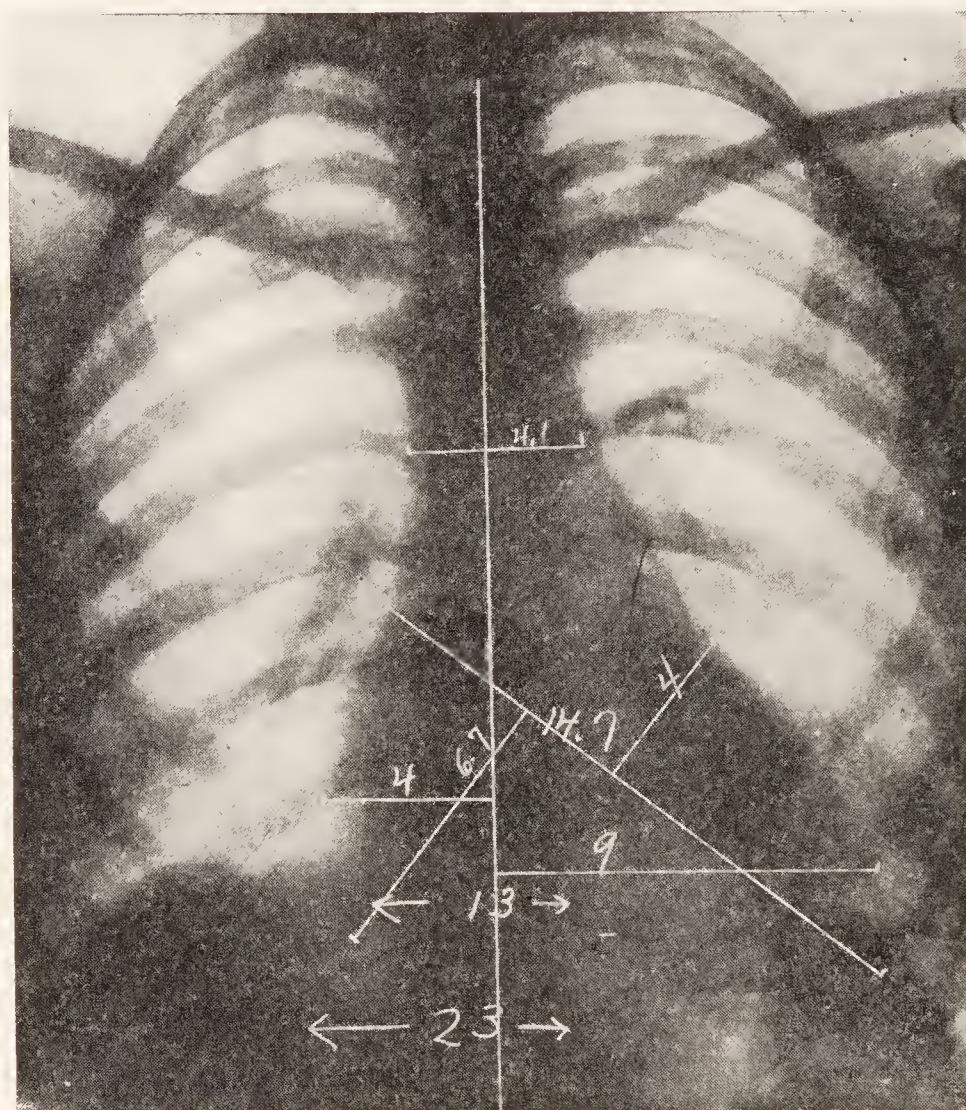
Necropsy 4152. Chronic adhesive pericarditis with hypertrophy and dilatation of the heart. Measurements by X-ray at seven feet six months before death. (Roentgenological Department, Massachusetts General Hospital.)
